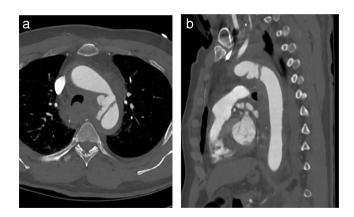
Preoperative chest CTA showing partial transection of the aorta (Grade III), 1.5 cm distal to the left subclavian artery. (a) Axial view. (b) Sagittal view.
